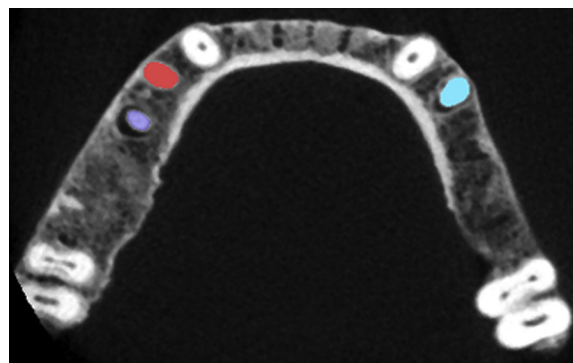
Cone beam computed tomography scan of mandible M2.
